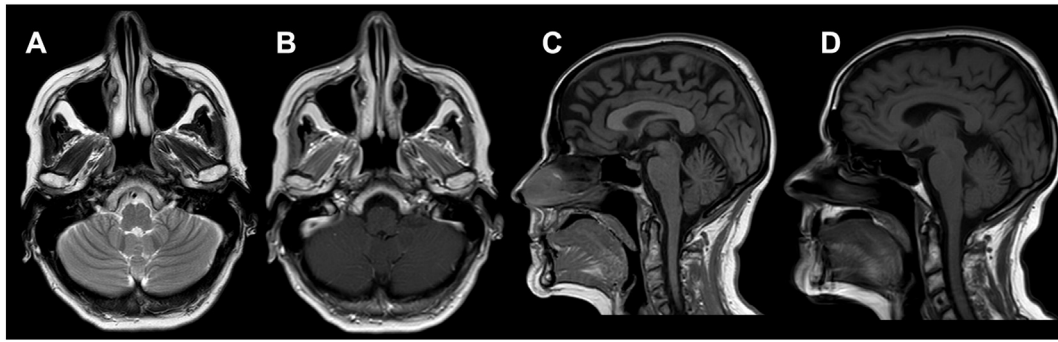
Brain MRI. At diagnosis axial T2 (A) and axial T1-gadolinium (B) did not reveal structural abnormalities or contrast enhancement. In sagittal slices, the volume of the cerebellar vermis was stable in a control (D) at 10 months from clinical onset, 6 weeks after the first neuroimaging (C).
